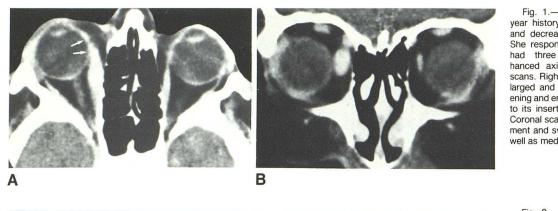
36-year-old woman with 1year history of pain, swelling, redness, and decreased abduction of right eye. She responded to steroids initially, but had three recurrences. Contrast-enhanced axial (A) and coronal (B) CT scans. Right medial rectus muscle is enlarged and noticeably enhanced. Thickening and enhancement of muscle tendon to its insertion into globe wall (*arrows*). Coronal scan shows prominent enhancement and swelling of superior oblique as well as medial rectus muscle.
